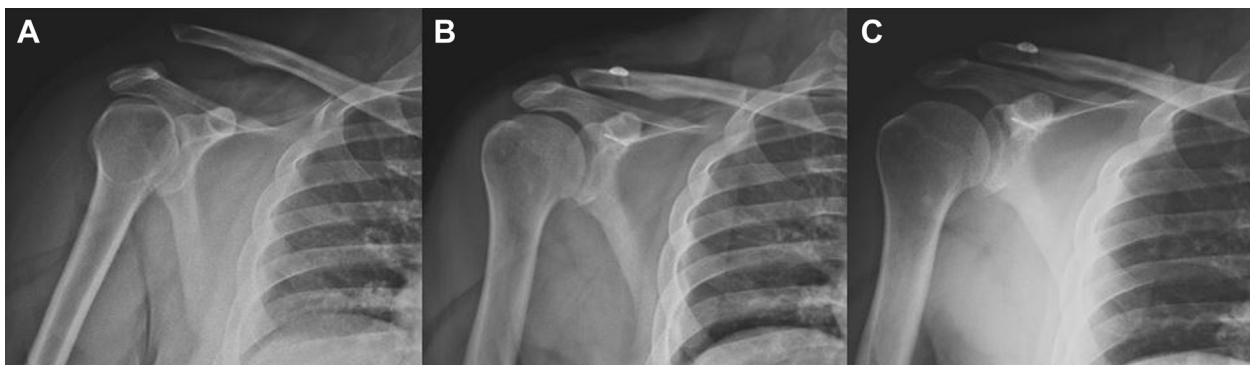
(A–C) Radiographic projections in right shoulder of patient classified as “without changes.”
